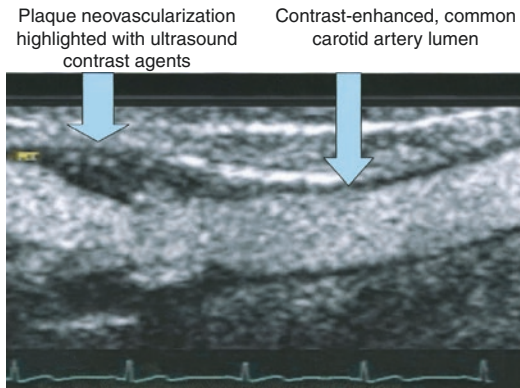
Ultrasound contrast agents highlight the vessel lumen and reveal intraplaque angiogenesis arising from the vasa vasorum. Feinstein [67]
